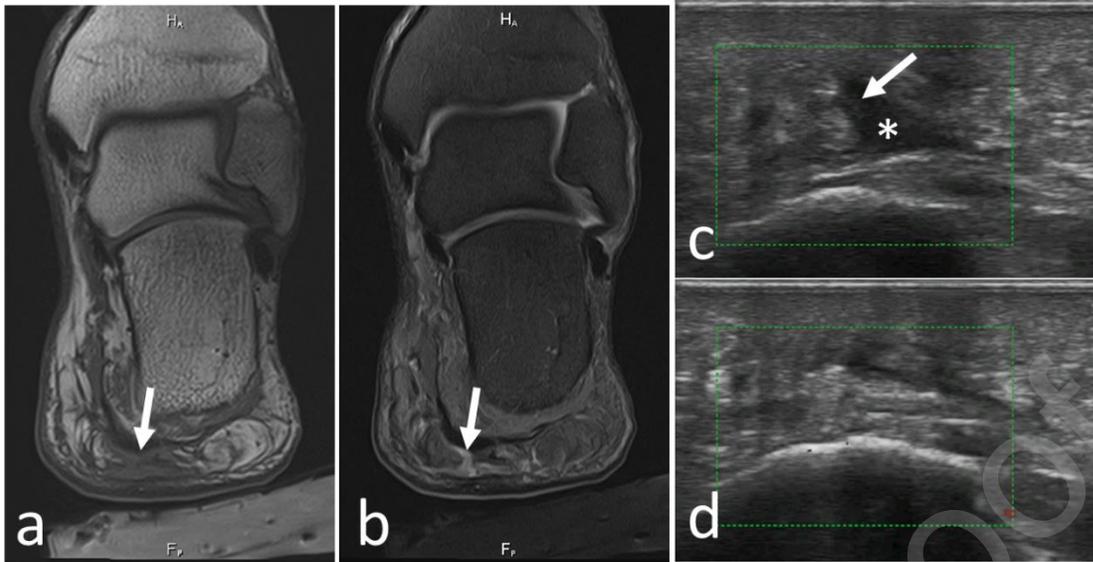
Heel fat with septal defect injury (arrows) and pseudocystic fluid (*) (case 7). Coronal T1 (a) and coronal T2 (b) MRI. Long-axis US without (c) and with probe pressure showing fluid disappearance (d) similarly to the defect observed when wandering.
